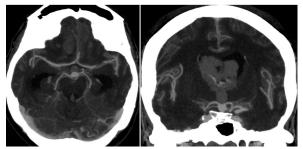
CT cerebral angiographic image showing basilar artery bifurcation saccular aneurysm which is ruptured with associated SAH at prepontine cistern, adjacent sulcal spaces & with extension into bilateral lateral, 3rd & 4th ventricles.
